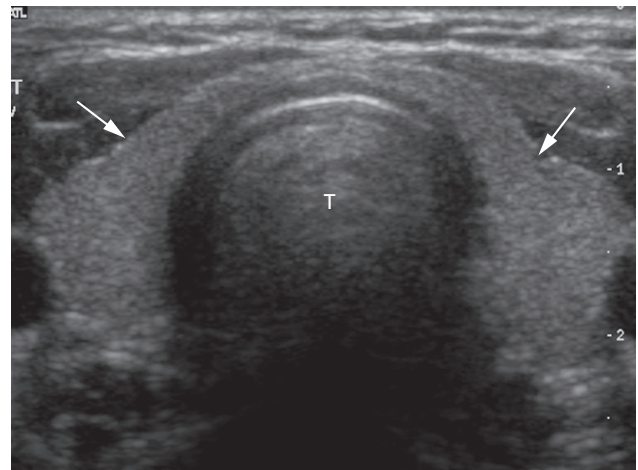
Normal ultrasound of thyroid. The two lobes of the thyroid (arrows) lie on either side of the trachea (T).
